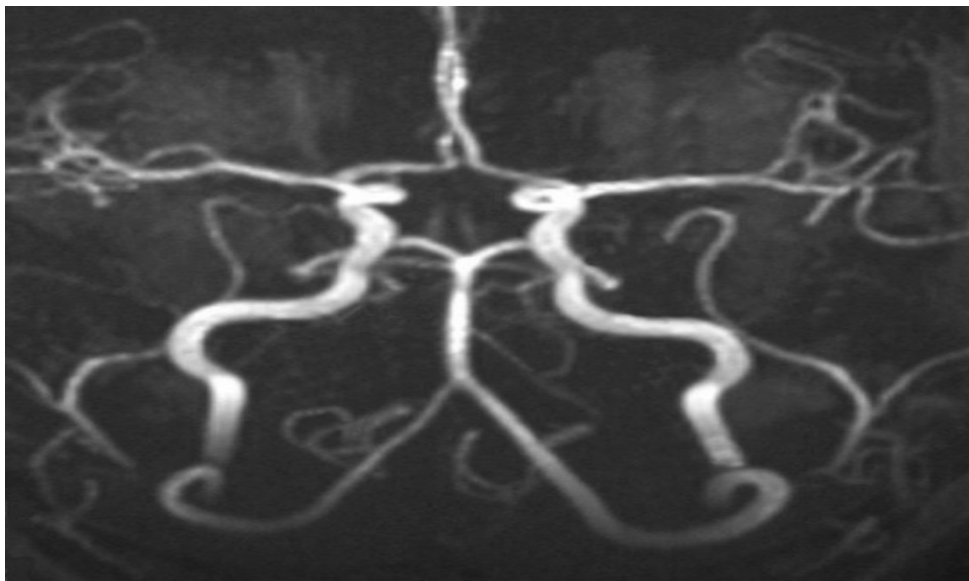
Circle of Willis MRI Image
